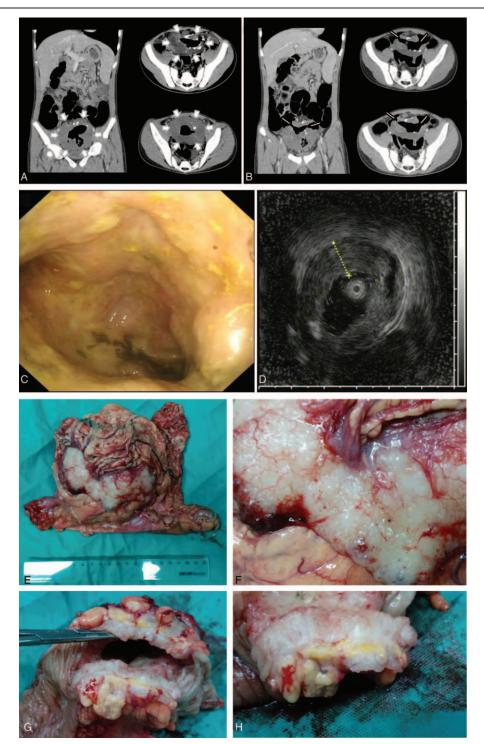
CT scan of the abdomen (A and B). (A) The thickened transverse colonic wall forms a round and hollow mass (arrows marked). (B) The proximal and distal intestinal lumen (arrows) within the mass is interconnected. Endoscopic view (C and D). (C) The circumferential neoplasma is observed with the lumen colon distorted and narrowed. The stenotic lesion is in front of the endoscope. (D) The ultrasound scan shows the circumferentially thickened colonic wall with the maximal thickness 2.8 cm (the dotted yellow line). The layers of the colonic wall were disappeared. Macroscopic features (E–H). \in The tumor with a 12 cm diameter is removed by radical resection from the transverse colon. It is rubbery, jellylike, and spherical. (F) A close-up for the tumor shows its granular, jellylike, and semi-transparent appearance. (G) Opened lengthwise, featuring a hollowed, interconnected with the proximal and distal colonic lumen. (H) The mucosa is granular, the serosa puckered, and the mesocolic/pericolic fat indurated.
